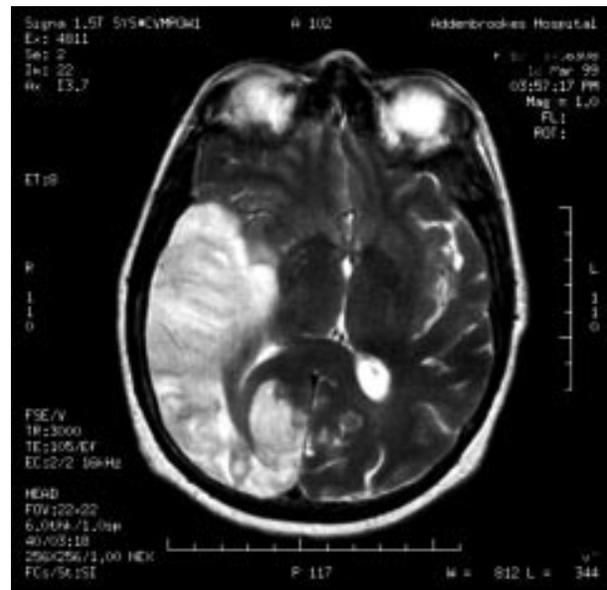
Brain magnetic resonance imaging showing a large well demarcated intra-axial high signal T2 weighted lesion occupying the bulk of the right temporal lobe, centred mainly on cortex and underlying white matter and sparing the temporal pole and mesial temporal structures but extending into the parietal, occipital, and posterior frontal regions.
